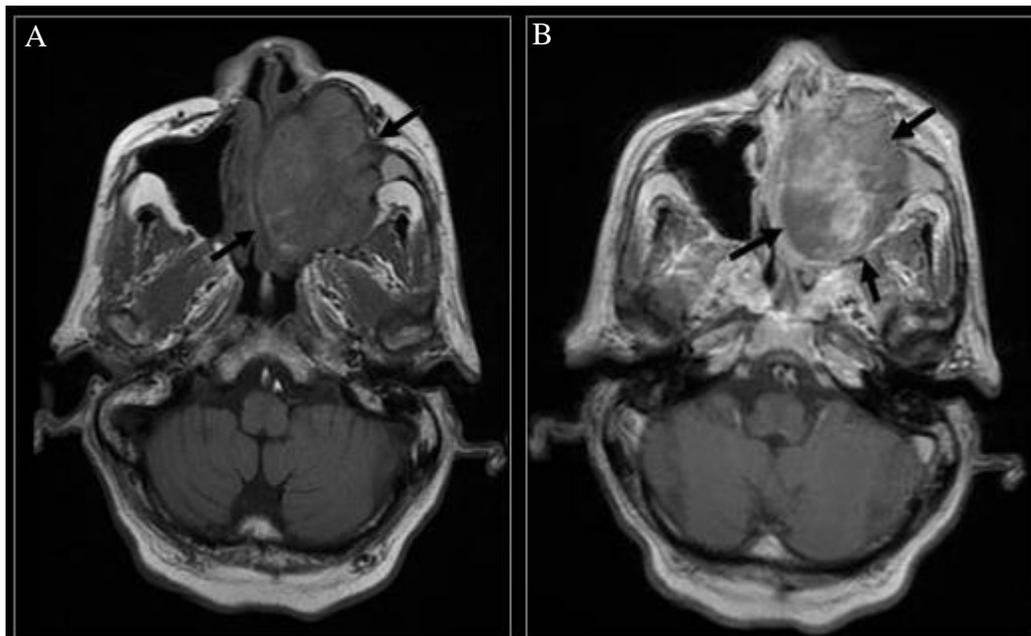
Axial spin-echo T1-weighted MR (A) pre-gadolinium and (B) post-gadolinium images of the nasal cavity and maxillary antrum (B) showing tumor mass in the left maxillary antrum and nasal cavity (black arrows) returns mixed signal intensity and inhomogeneous enhancement. This mass extends medially into the left nasal cavity causing obstruction of the left nasal cavity and deviation of nasal septum to the right. Anteriorly it causes bowing of the anterior wall of the maxillary sinus.
